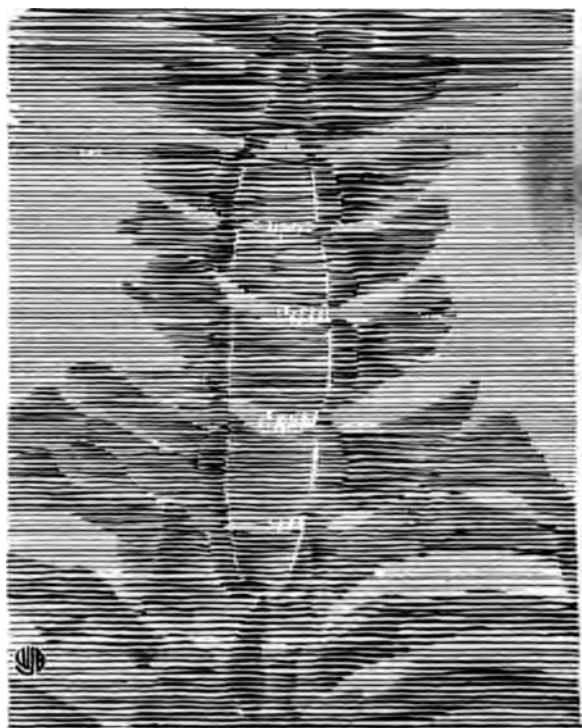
X-RAY SKETCH OF CERVICAL REGION AFTER LAMINECTOMY.
